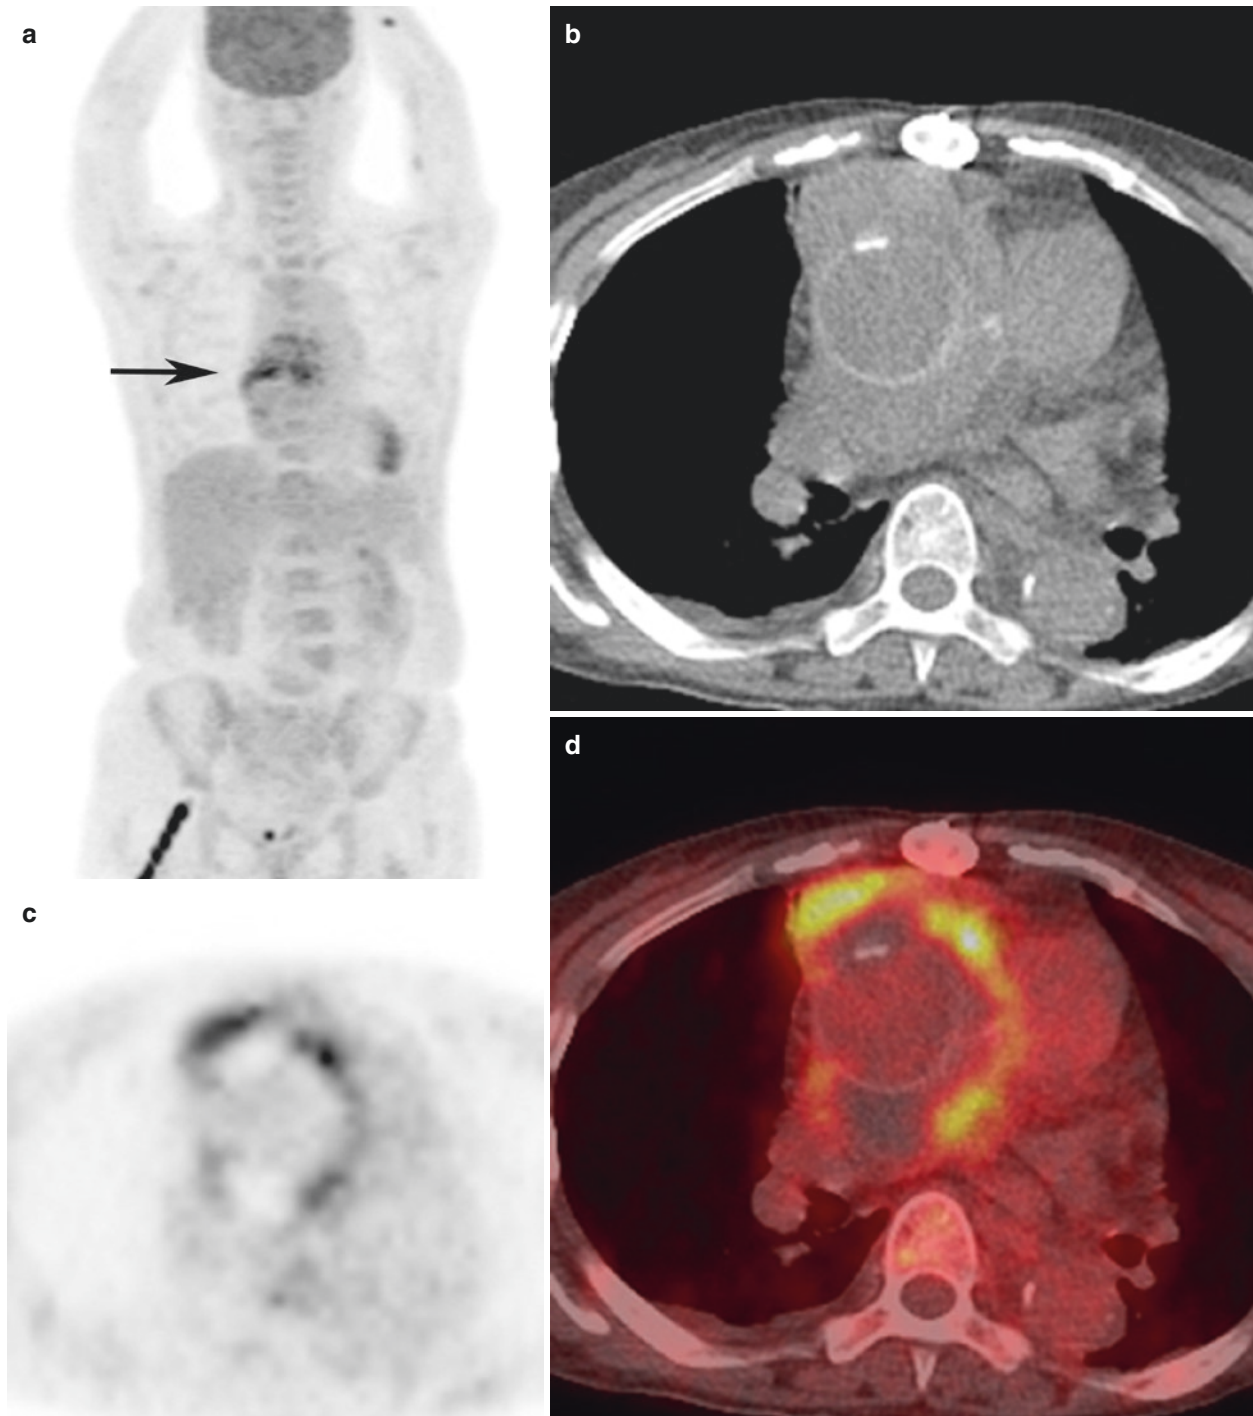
A maximum intensity projection image (a), axial images of CT (b), PET (c), and fusion (d) demonstrate increased tracer uptake in the mediastinum (a, arrow), especially around the ascending aorta, where a soft tissue density mass is also noted. Because CT images obtained 2 weeks before demonstrated no soft tissue density mass
